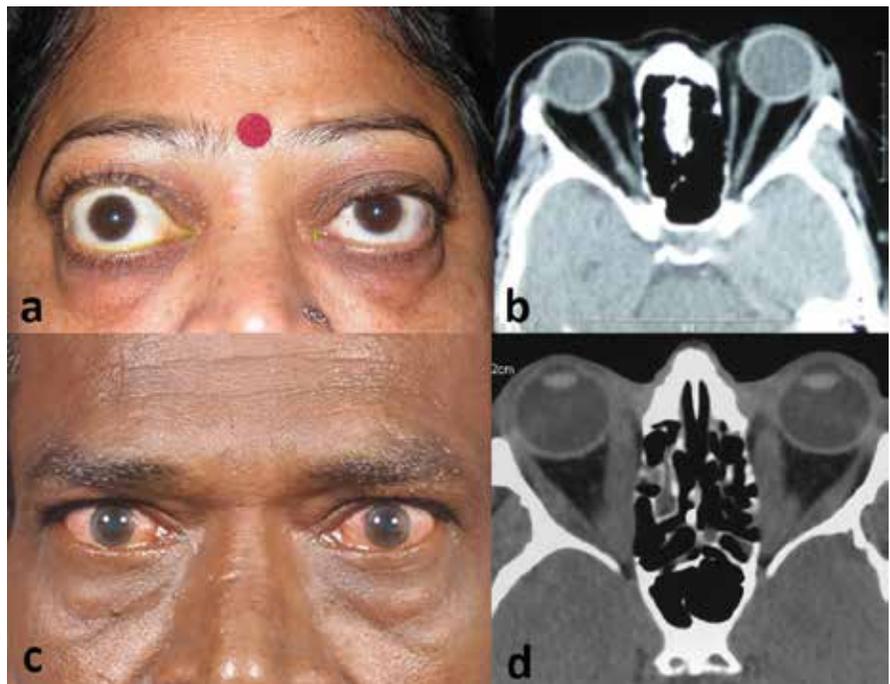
Orbital imaging findings in case of GO. Bilateral proptosis in a female patient with TED (Figure 7a) and CT scan showing increased orbital fat spaces and stretching of the optic nerve with minimal extraocular muscle thickening suggesting a predominantly fat disease (Figure 7b). Eyelid retraction and severe extraocular movement restriction and optic neuropathy with minimal proptosis in a male patient with TED (Figure 7c) and the corresponding CT scan showing massive enlargement of extraocular muscles causing crowding of the orbital apex in a predominantly muscle disease (Figure 7d).
